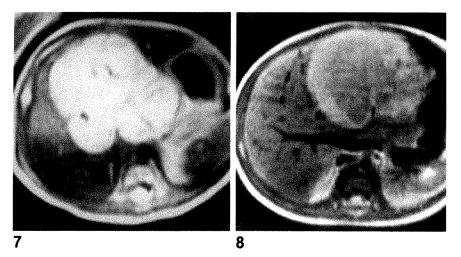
Specificity of T2-weighted image in neonate with cavernous hemangioma. Axial SE T2-weighted image (1500/56) shows marked hyperintensity of lesion (equal or higher than subcutaneous fat) characteristic of hemangioma.
